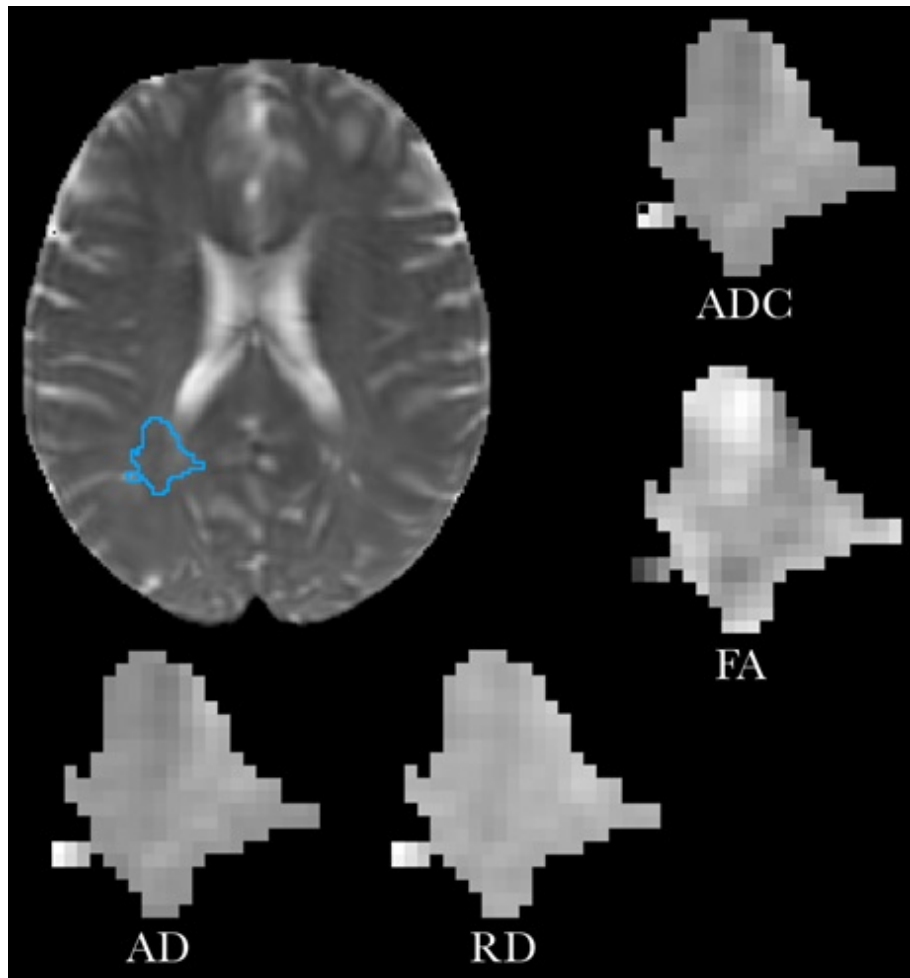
Example of Lesion and Brain Texture shown in dataset p01c1 slice 100 for each available MRI protocol.
